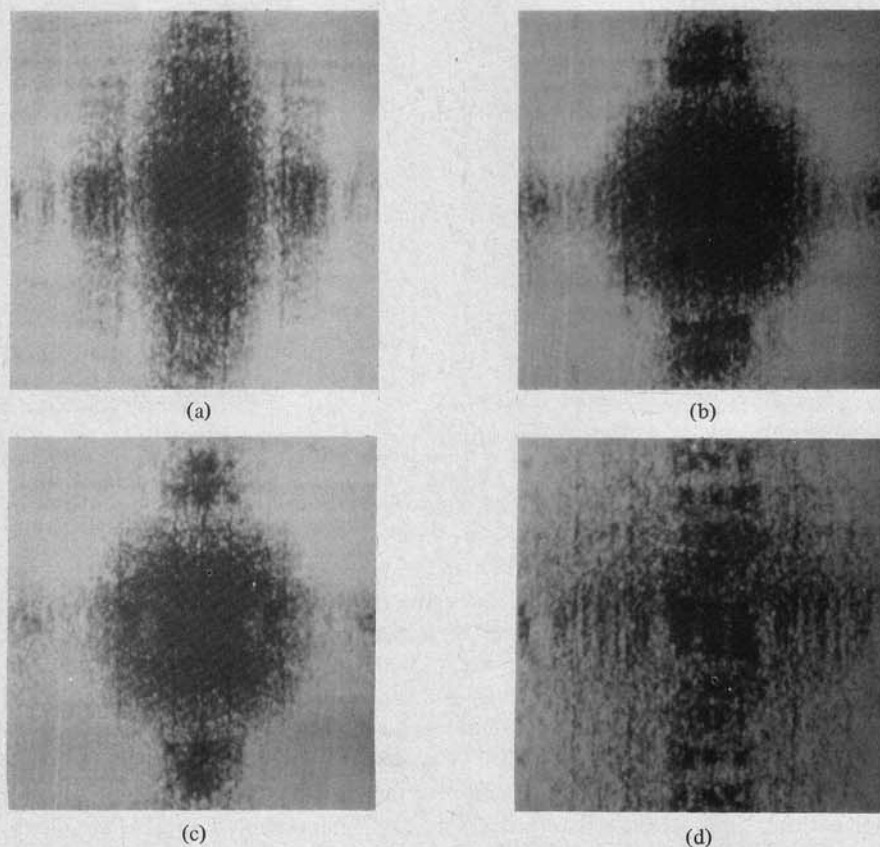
(a)-(d) Two-dimensional Fourier transform (in dB) of the radiographs in Fig. 9(a)-(d), respectively.
